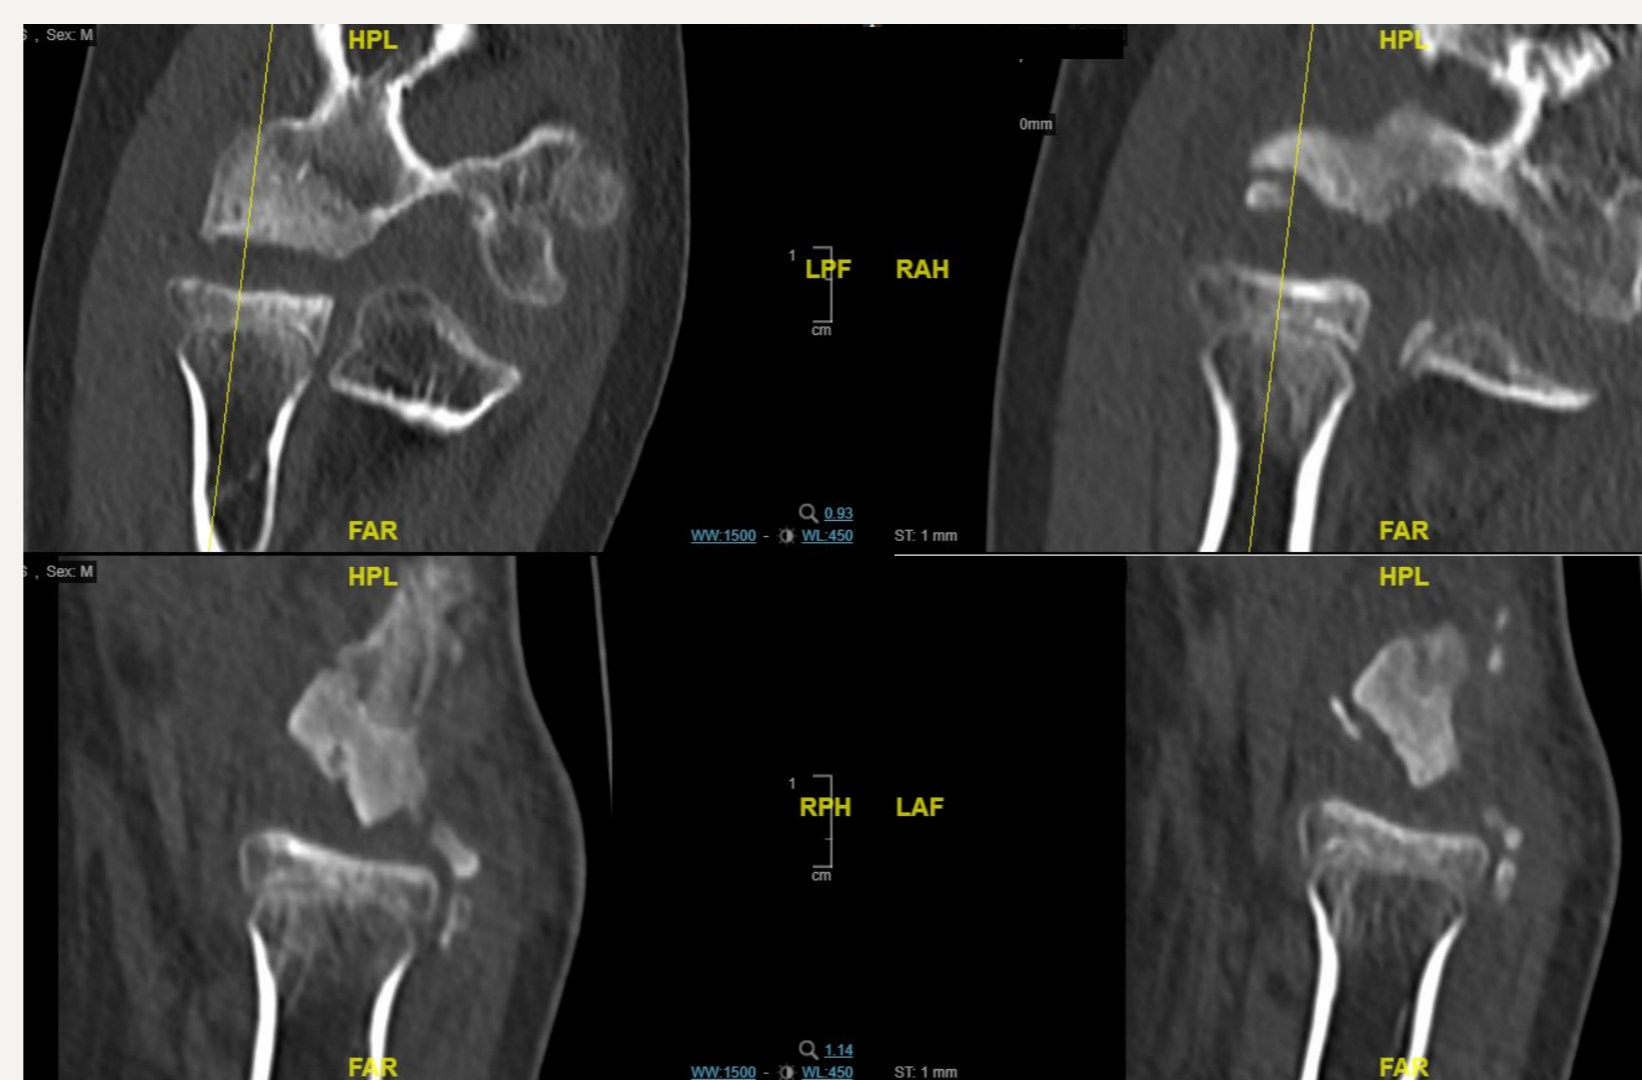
CT-scan, osteochondral lesion in the proximity of the humeral capitulum with dorsal dislocation of the fragments, dysplastic deformity of the humeral trochlea
